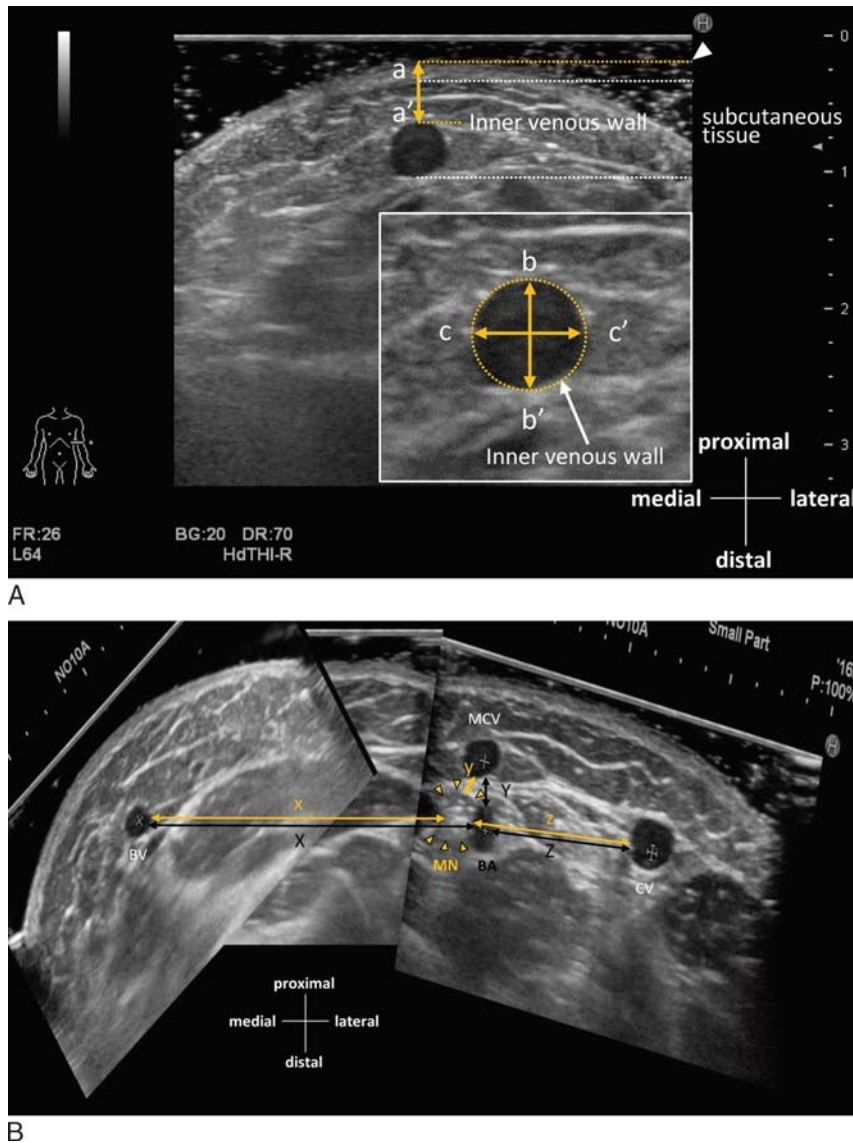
Ultrasound image analysis. A, The ultrasound image shows the measurement of depth and diameter. a-a' shows the minimal distance between each superficial vein and the skin (vein depth). b-b' shows the minimum diameter of each superficial vein, and c-c' shows the maximum diameter of each superficial vein. B, The ultrasound image shows the measurement of the distance between each superficial vein and the median nerve or brachial artery. The yellow straight lines show the shortest distance between each superficial vein and the median nerve (x = the distance between the basilic vein and median nerve, y = the distance between the median cubital vein and median nerve, and z = the distance between the cephalic vein and median nerve). The black straight lines show the shortest distance between each superficial vein and the brachial artery (X = the distance between the basilic vein and brachial artery, Y = the distance between the median cubital vein and brachial artery, and Z = the distance between the cephalic vein and brachial artery). BA, brachial artery; BV, basilic vein; CV, cephalic vein; MCV, median cubital vein; MN, median nerve.
